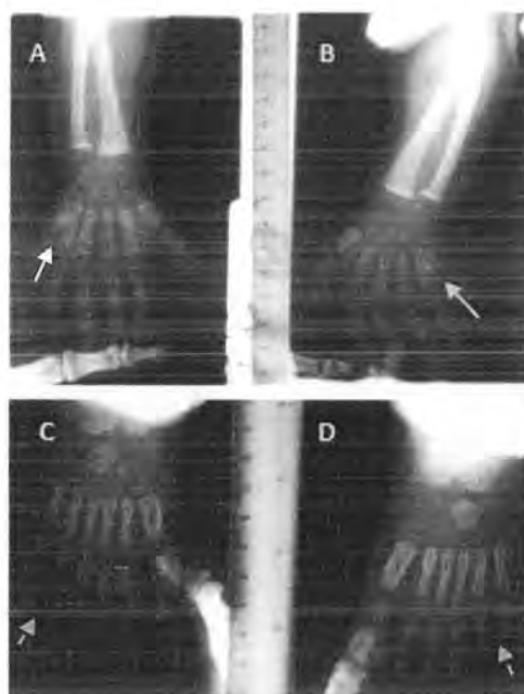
Radiographs of hands and feet of Subject III-1
